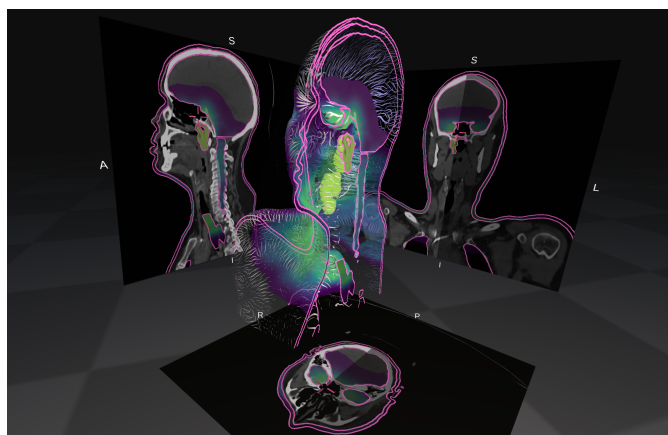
Three axis-aligned planes are rendered on the far sides of the volume data cube, one each for the sagittal, coronal, and axial planes. The volume is also cut by a sagittal plane. Every plane includes: 1. A uniform thickness outline for all currently selected structures. 2. The dose at that slice rendered in color. 3. CT data at the slice rendered in grayscale.
